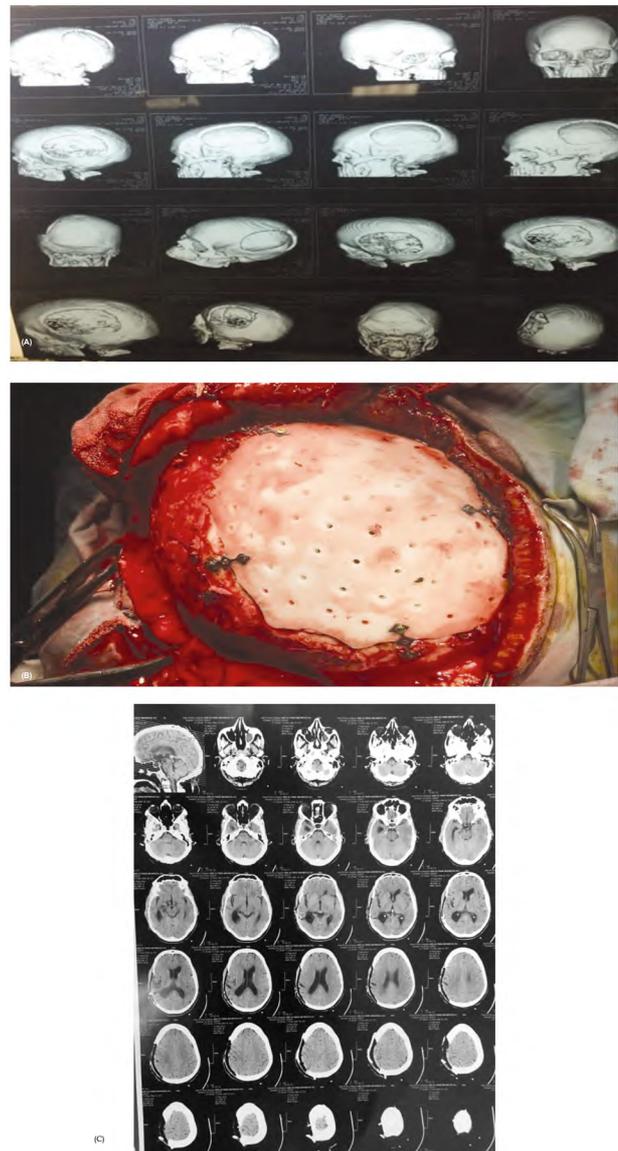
44 years old male patient with history of chronic brain abscess operated upon by excision 1 year prior to admission followed by osteomyelitis 1 year prior to admission, (A) Preoperative CT 3D reconstruction showing large right fronto-parietal defect (B) Intraoperative placement of the PEEK implant and fixation to bone margins with miniplates and screws (C) Follow-up axial CT showing proper fitting of the construct.
